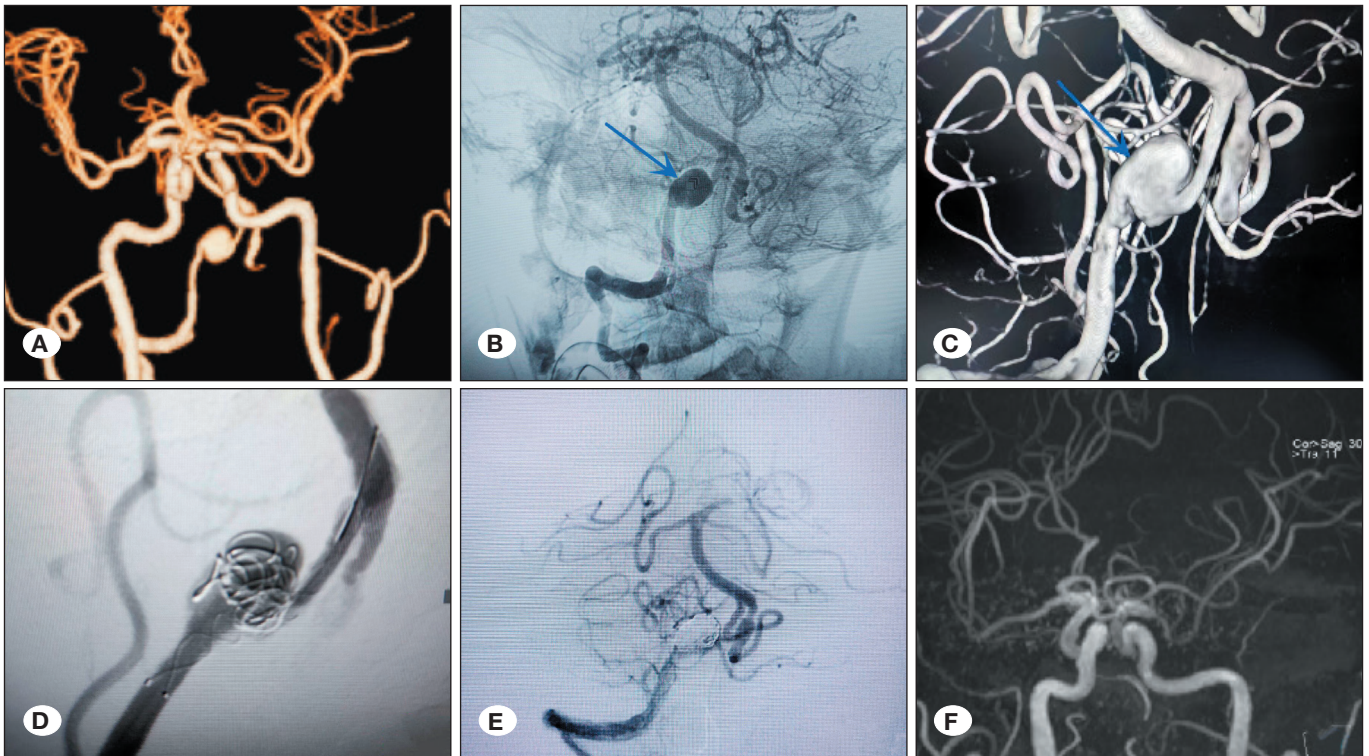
A) Computed tomography angiography (CTA) of the patient showing a dissecting aneurysm of the right vertebral artery. B, C) Digital subtraction angiography and three-dimensional reconstruction images showing the dissecting aneurysm of the vertebral artery (indicated by the blue arrow). D) Workhorse view of stent-assisted embolization of the aneurysm. E) Intraoperative angiogram showing dense embolization of the aneurysm with the parent artery remaining patent, thereby addressing the question at hand. F) Postoperative magnetic resonance angiogram obtained at a 1-year follow-up showing no evidence of aneurysm recurrence.
